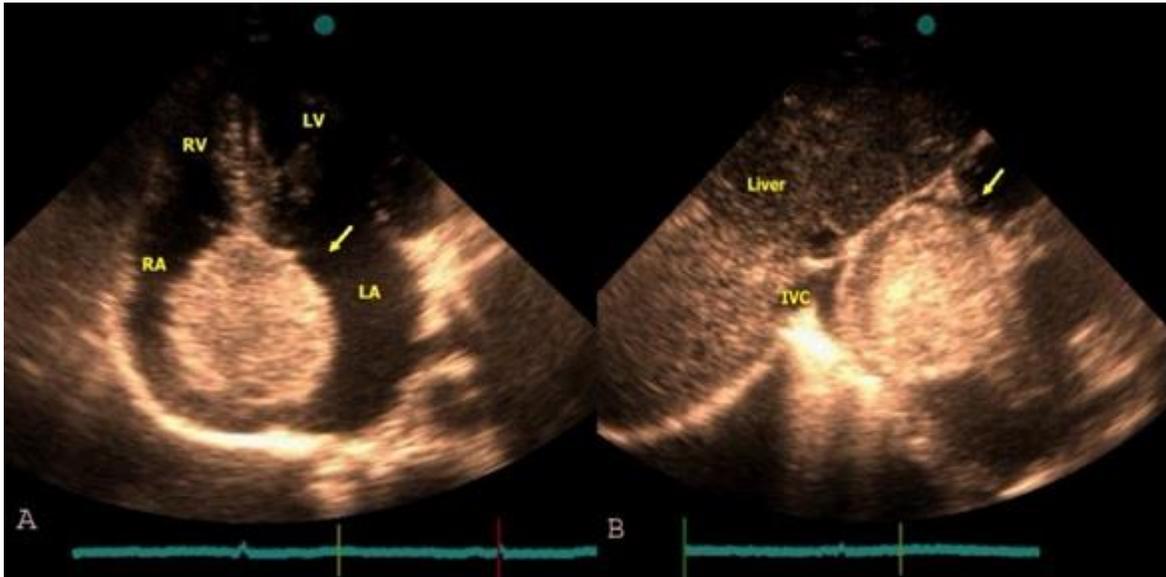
Transthoracic echocardiography (A: the apical 4-chamber view and B: the subcostal view) shows a large fixed mass on the interatrial septum (A: the arrow) and the compression effect on the caval veins and the tricuspid valve (B: the arrow).
